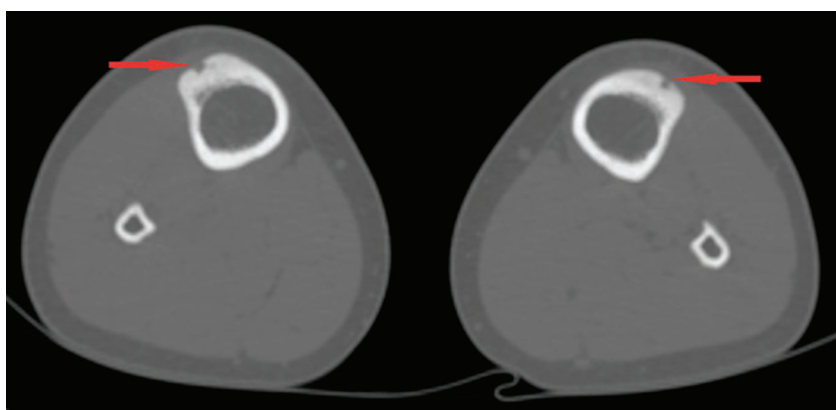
Axial CT through the proximal third of the bilateral tibias shows symmetric prominent vascular channels of the anterolateral tibias (arrows).
